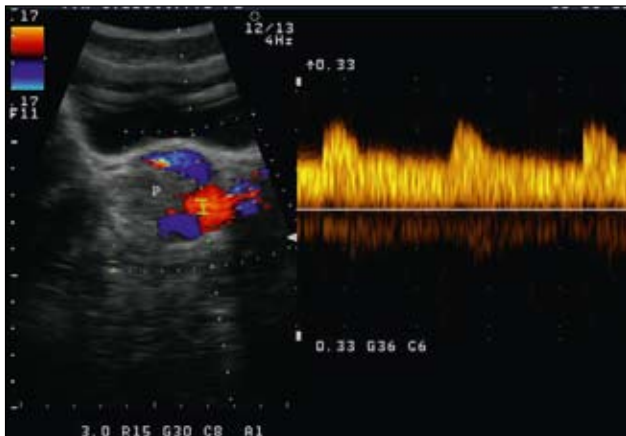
Color flow Doppler sonography with transrectal “end-fire” probe. Dilatated vases with turbulent blood flow near the left side of the prostate (P).
